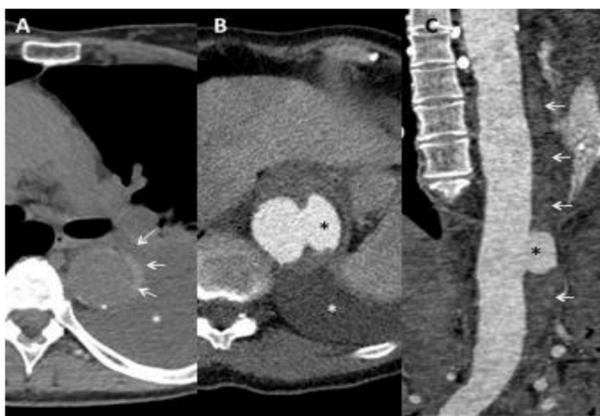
Axial CT at different levels of the thoracic aorta before (A) and after (B) contrast administration. IMH is seen as a crescent of high attenuation within the wall of the aorta (A). A large PAU is seen in the distal descending thoracic aorta (B and C, black asterisk).
